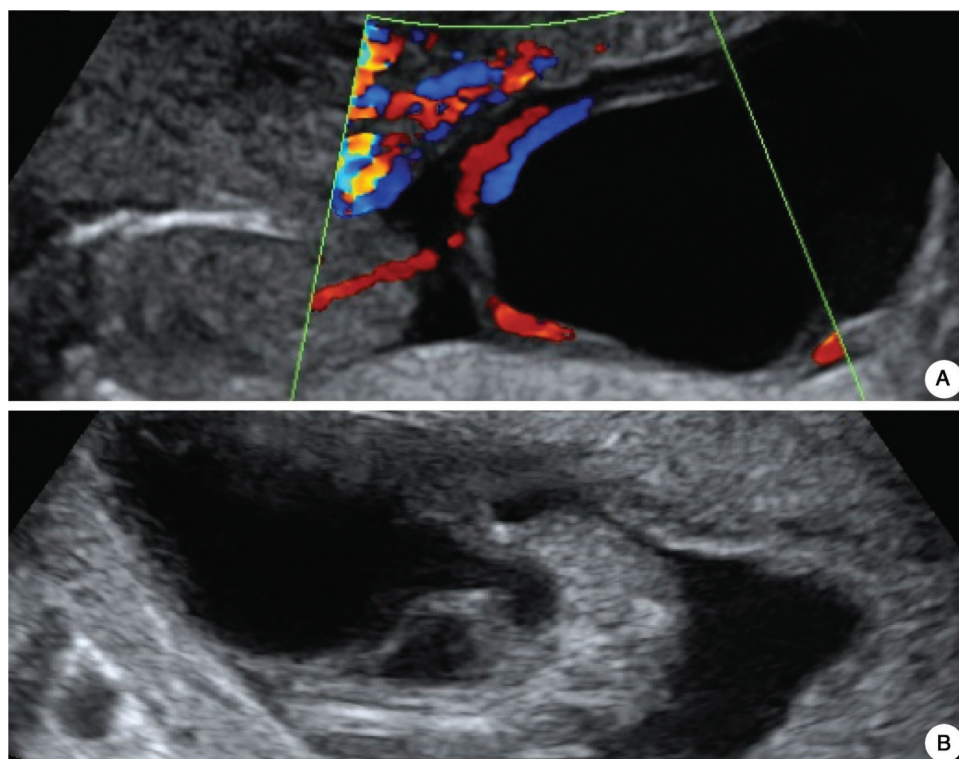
Ultrasound imaging of the pregnant woman. A Umbilical vessels identified using Color Doppler located around the cyst. B Connection between the cyst and the bladder at 15⁺¹ week.
